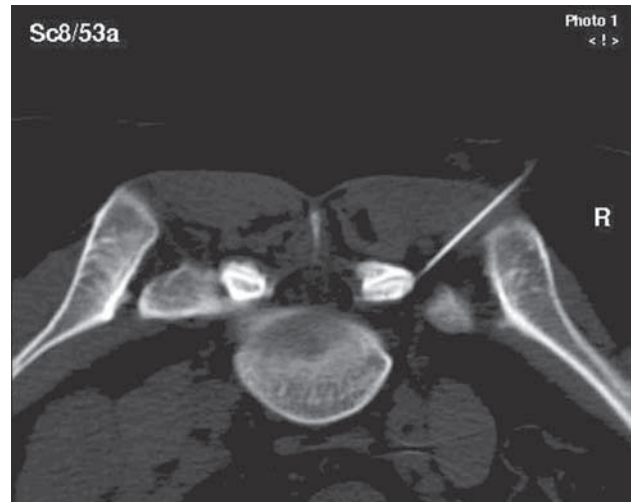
CT guided facet injection demonstrating needle positioned in right L5-S1 facet joint.
